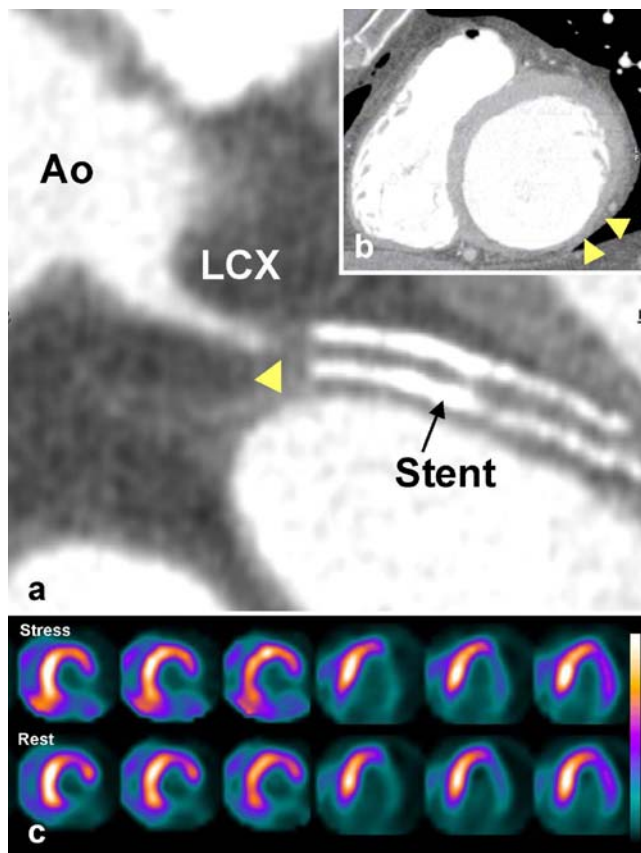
a Curved two-dimensional reformatted 64-slice CT image of the LCX arising from the aorta (*Ao*) with complete occlusion proximal to the stent (*arrowhead*). b Multiplanar reformatted CT image in the two-chamber short axis view, showing a thinned inferolateral myocardium (*arrowheads*) correlating with the perfusion defect on MPI images. c Short-axis (*left*) and horizontal long axis (*right*) slices of MPI stress and rest images obtained with ^{99m}Tc -tetrofosmin revealing a large fixed inferolateral perfusion defect
